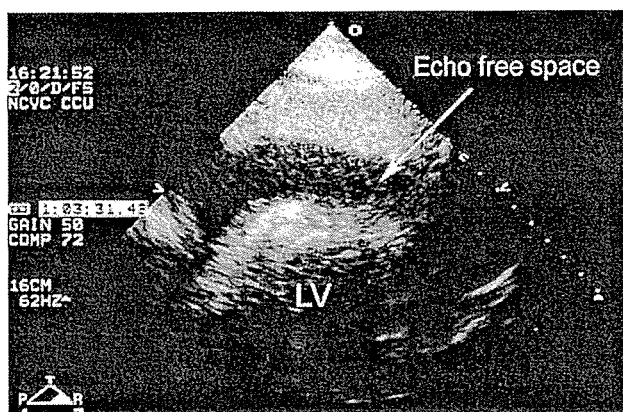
Echocardiography showing pericardial effusion with findings of cardiac tamponade, indicating cardiac rupture (arrows). LV, left ventricle
